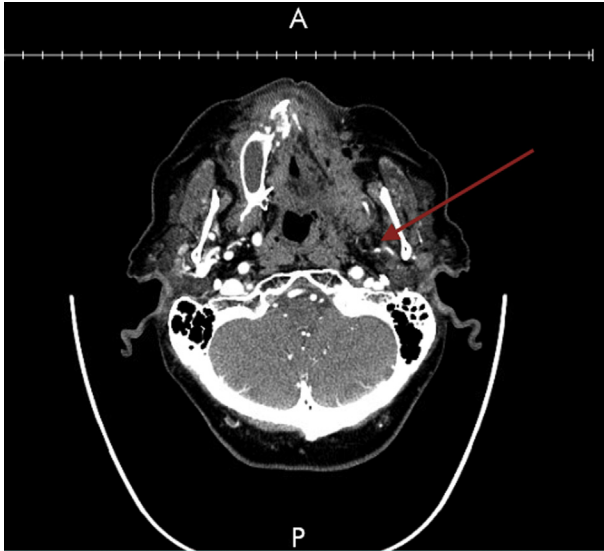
Neck CTA demonstrating occlusion of a branch of the left maxillary artery. Abbreviation: CTA, computed tomography angiography.
